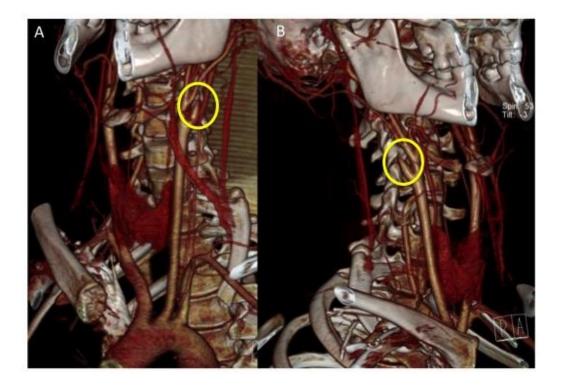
Reconstruction of a cervical angio-CT scan of a patient diagnosed with GS at Hospital Pediátrico. The image shows a bilateral occlusion of the internal carotid arteries (A - left; B- right), with the yellow circle highlighting the typical pencil point image that can be identified in these situations.
